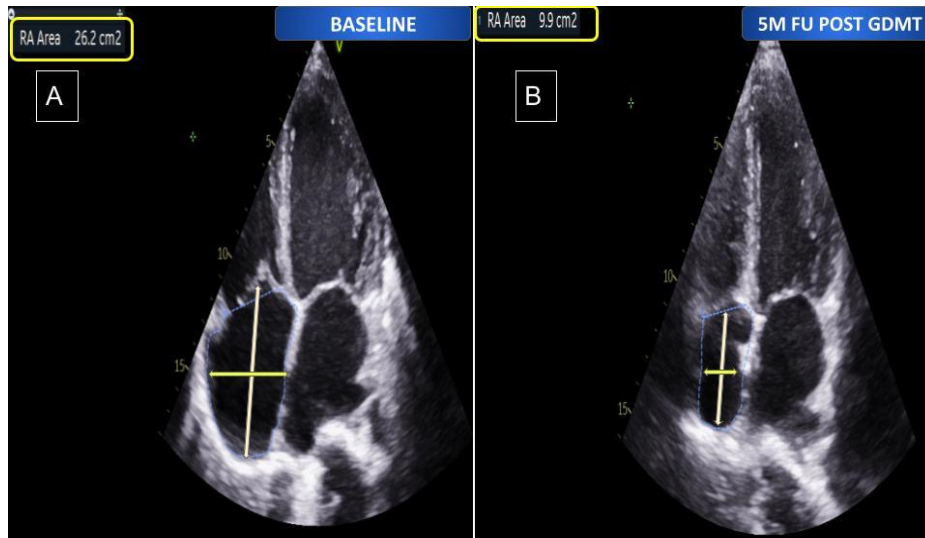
Transthoracic echocardiography. Left panel: Baseline echocardiography revealed RA dilation with RA area of 26.2 cm²; Right panel: Post-treatment echocardiography evaluation showed a reduction in RA area to 9.9 cm². RA: right atrial.
